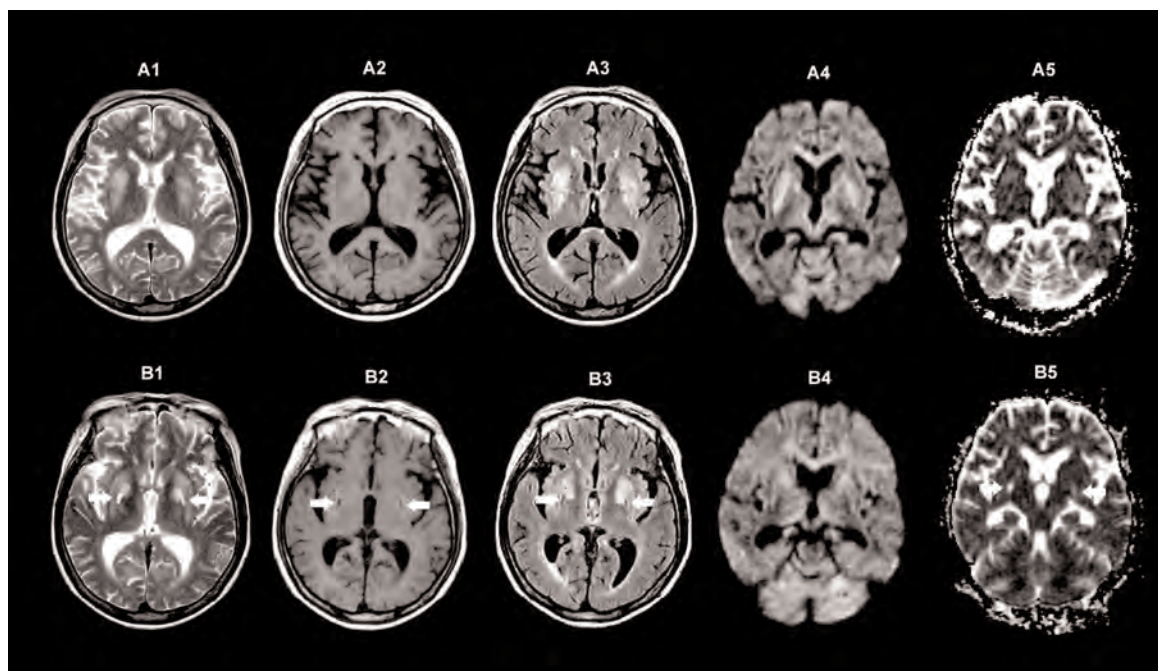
1. T2-weighted image, 2. T1-weighted image, 3. fluid-attenuated inversion recovery (FLAIR) image, 4. diffusion-weighted image, 5. apparent diffusion coefficient (ADC) map. Initial brain MR imaging demonstrating bilateral basal ganglia lesions (A1-5). These areas show hyperintensities on T2-, diffusion-weighted, and FLAIR images, while the same lesions show hypointensity on T1-weighted image. On ADC map, the corresponding areas have slightly increased signal intensities. Follow up MR imaging (B 1-5) performed 3 months after onset shows decreased signal change and size of the focal edema in basal ganglia compared with the previous study. Discrete symmetrical signal changes over the bilateral globus pallidus are noted (arrows; hyperintensities on T2- weighted image and ADC map, and hypointensities on T1-weighted, and FLAIR images).
